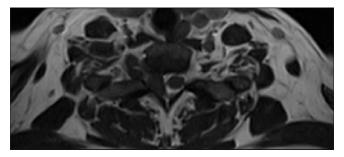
T2-weighted magnetic resonance imaging of the cervical spine showing a spinal mass with a clear plane between the normal cord and the lesion.
